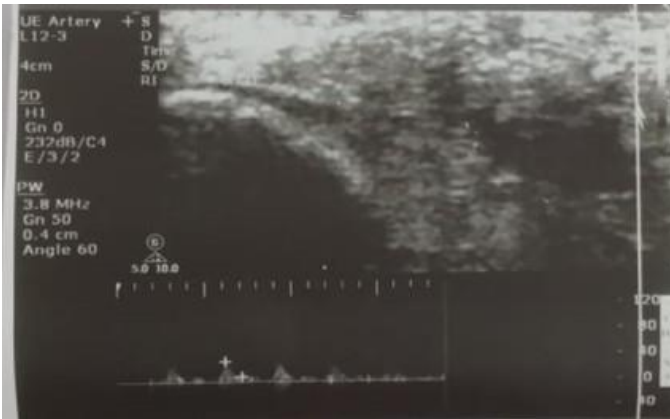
The ultrasonography of radial artery
